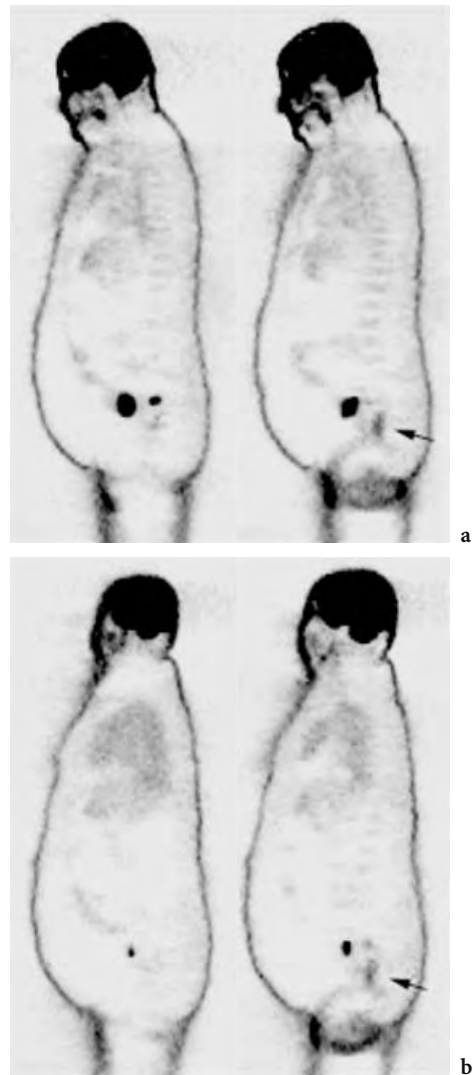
A 70-year-old white male with rectal cancer. cT3N1M0 disease on CT. Sagittal slices before (a) and after (b) radiation therapy. This whole body PET detected two affected lymph nodes superior of the tumor, which were outside the field of view of 101 mm on the dynamic scan. Note the decrease in metabolic activity of both the tumor (*arrow*) and lymph nodes. Average tumor glucose utilization was 178 ng/min/ml before (a) and 72 ng/min/ml after radiation therapy (ECAT 931 PET system)
